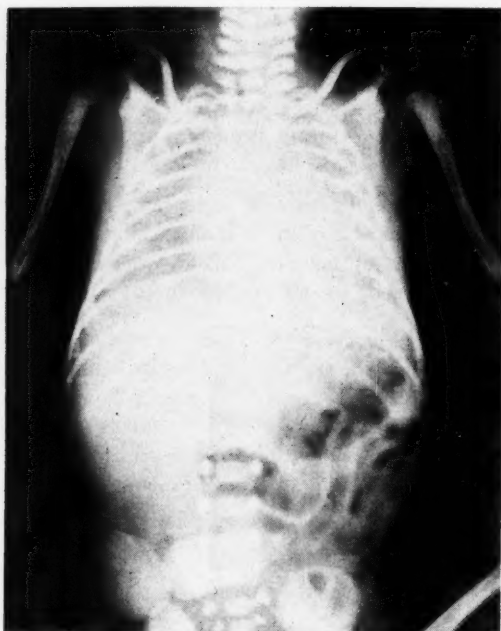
(Case 2) A premature with respiratory distress at eight hours at which time retraction developed. Radiographs and thoracotomy showed atelectatic changes compatible with the diagnosis of hyaline membrane disease. Autopsy showed secondary atelectasis with hyaline membrane lining of many alveoli.
